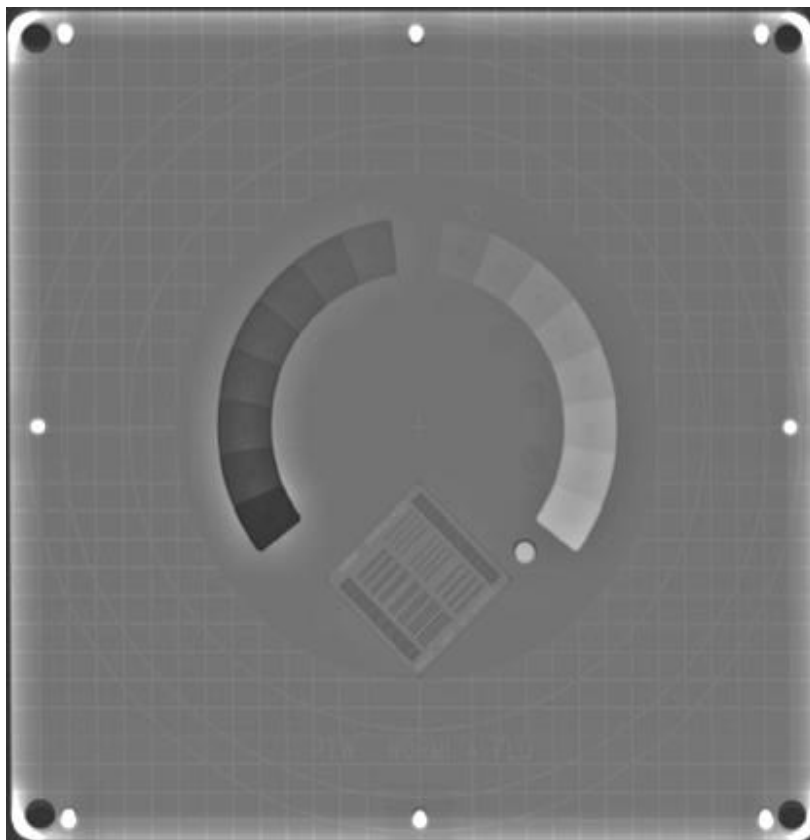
An X-ray image of the PTW Normi 4 FLU^{PLUS} test object
